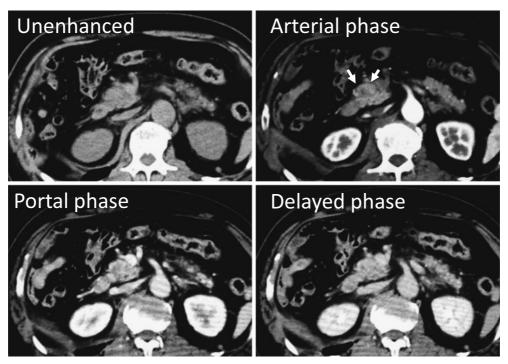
Dynamic contrast-enhanced CT showing a 20-mm heterogeneous tumor in the head of the pancreas (arrows in the arterial phase image).
